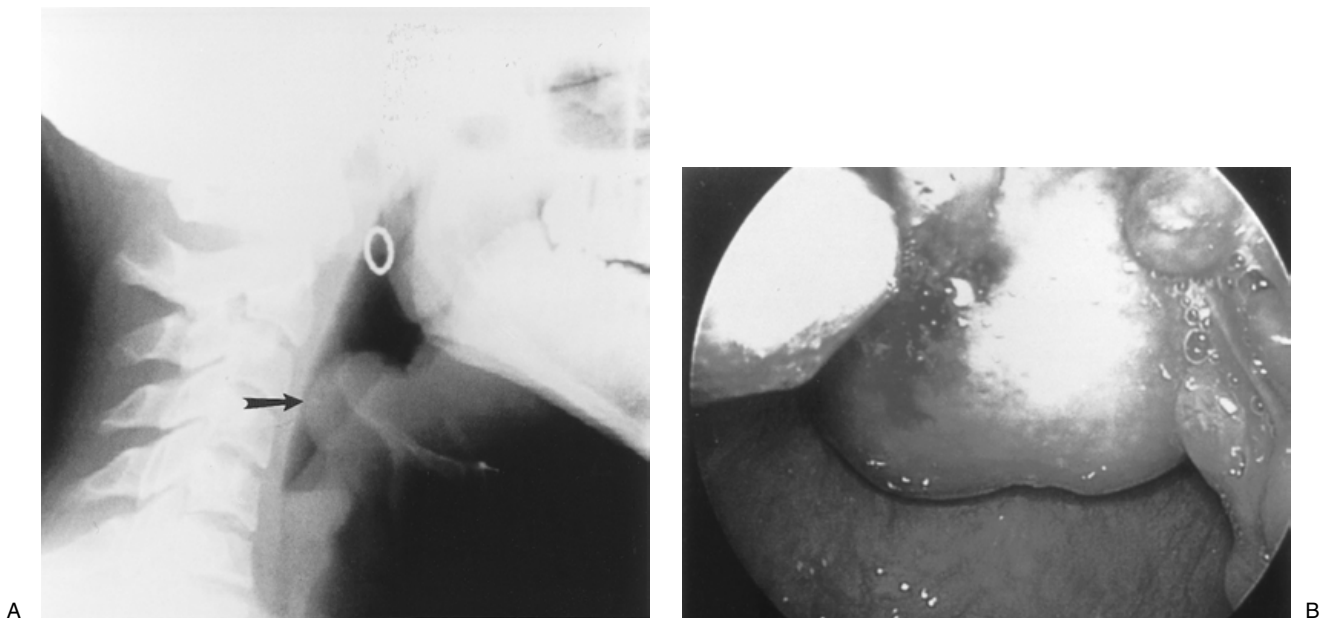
Lateral soft tissue radiographs of the neck reveal the classic “thumbprint” sign of the swollen epiglottis, indicative of acute supraglottitis.
